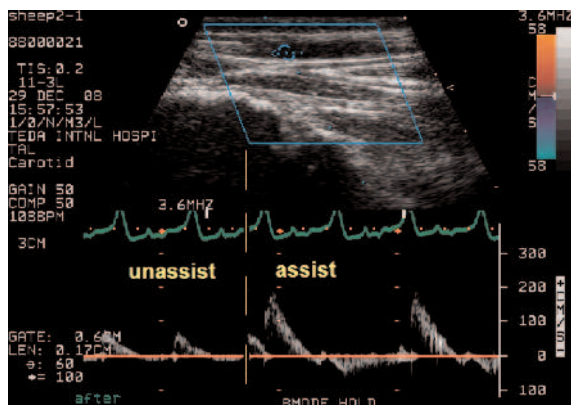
Measurement of left carotid artery blood flow changes before and after the counterpulsation assist with Color Doppler Ultrasound (CDU). Left carotid artery blood flow increased significantly after the counterpulsation assist.
